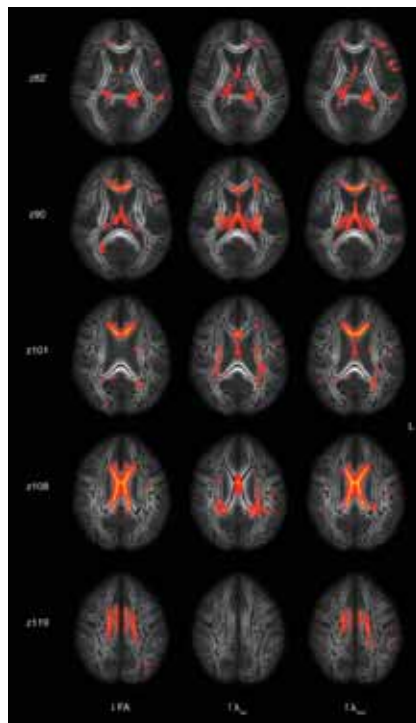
Global white matter atrophy and increased directional diffusivity. Axial projections of mean fractional anisotropy (FA) MRI images on which the white matter skeleton (black) is projected. Columns show regions where global white matter atrophy is associated with decreases in FA or increases in axial (λ_{ax}) and radial (λ_{rad}) diffusivity, respectively. Rows depict the same axial levels as Figure 2, in MNI coordinates (z). The first ($z= 82$) and second ($z= 90$) rows show decreases in FA in the hippocampal region and fornix associated with white matter atrophy, accompanied by increases of both λ_{ax} and λ_{rad} (yellow-to-red colors) in these regions. The third ($z= 101$) and fourth row ($z = 108$) show that reductions of FA in the corpus callosum and cingulate bundle are almost fully explained by increases in λ_{rad} in these regions, without accompanying changes in λ_{ax} . In contrast, λ_{ax} is increased in posterior periventricular regions ($z= 108$), without a marked change in λ_{rad} .
